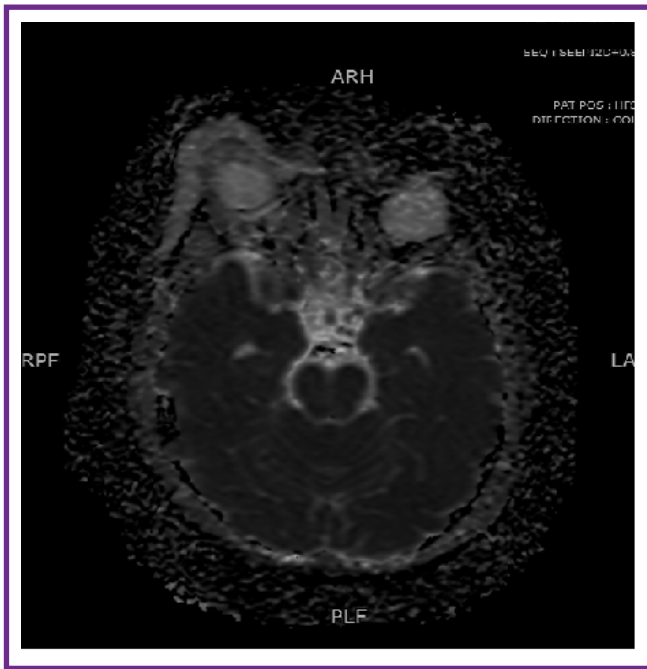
MRI Brain showing Right right-sided panophthalmitis with periorbital and retro-bulbar cellulitis.
